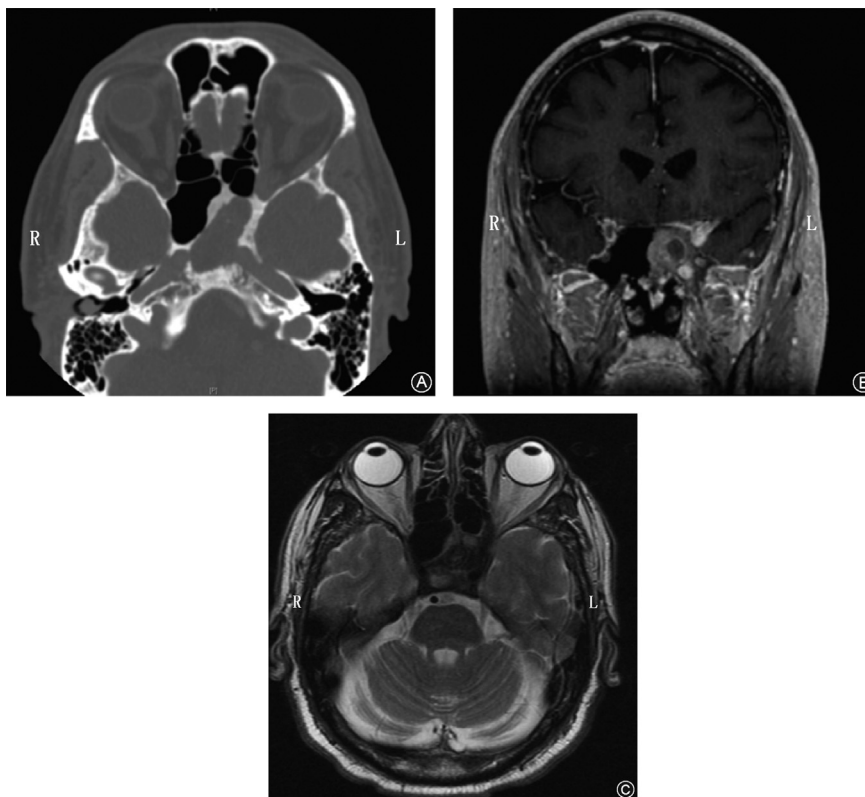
CT and MRI imaging for Case #2. A: Axial CT scan without contrast demonstrating left sphenoid opacification and bony erosion over the carotid. 1–2 spots of calcification can be seen; B: MRI T1 with contrast coronal view demonstrating left sphenoid opacification with heterogeneous signal pattern; C: MRI T2 axial view demonstrating complete signal drop out within left sphenoid, suggestive of dense left sphenoid fungal sinusitis and possible IFS given crescendo in symptoms.
